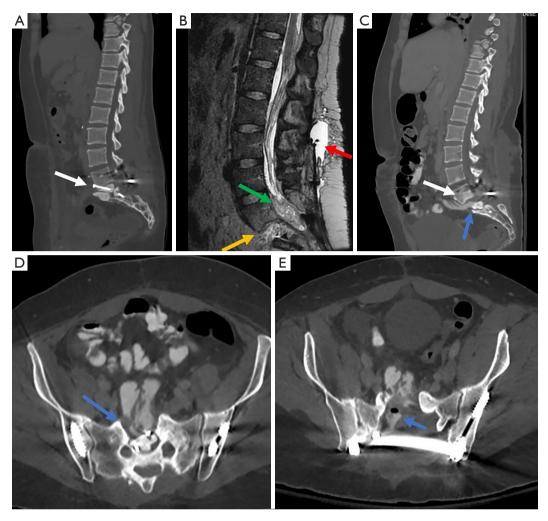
Demonstrative CT images revealing patient's presenting pathology. (A) Previous postoperative non-contrasted CT following giant cell tumor resection and small bowel resection demonstrating bone cement within the resection cavity secured with a ventral bone screw (white arrow). This CT was obtained 4-year prior to current presentation. (B) Sagittal T2 MRI L spine from present admission indicating small bowel invaginating through the previous lumbar defect (orange arrow), new development of posterior pseudomeningocele (red arrow) and fecal matter in the lumbar cistern (green arrow). (C-E) Sagittal and axial CT abdomen and pelvis with oral contrast from present admission demonstrating a loop of small bowel invaginating into the previous lumbosacral spine defect with direct communication (blue arrows) with the thecal sac. Note that the previous bone cement as well as the ventral cement screw seen on the lumbar spine CT in panel A are no longer present (white arrow). It was presumed to have eroded through the small intestine and been eliminated during a bowel movement. CT, computed tomography.
